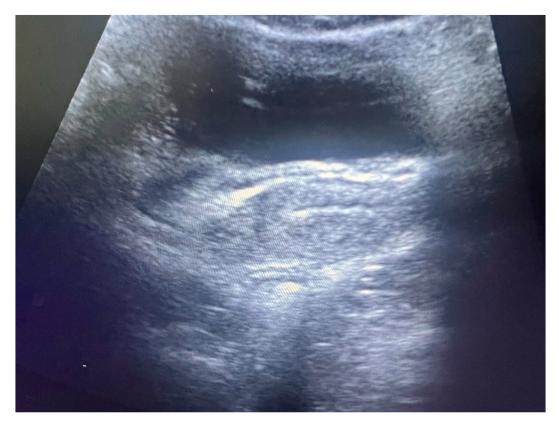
Ultrasonography showing the uterus, cervix, and vagina without echogenic fluid 5 months after surgery.
